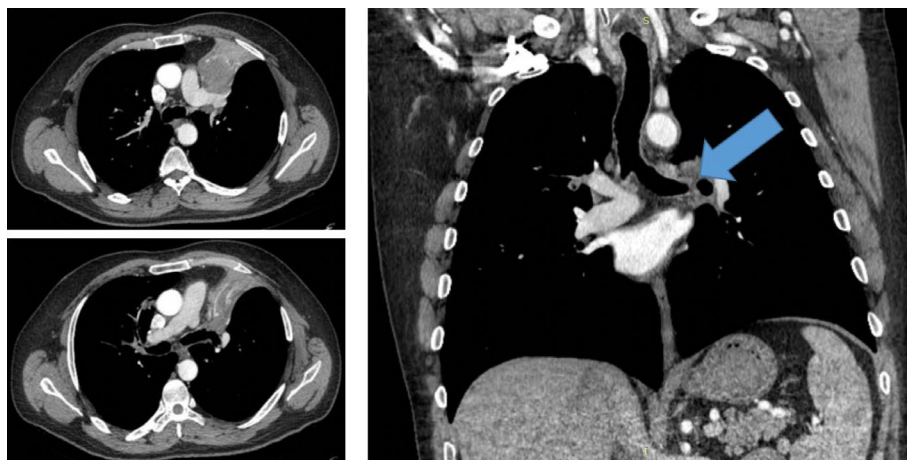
CT of TCO from 08/10/2018 (after induction chemoimmunotherapy).
